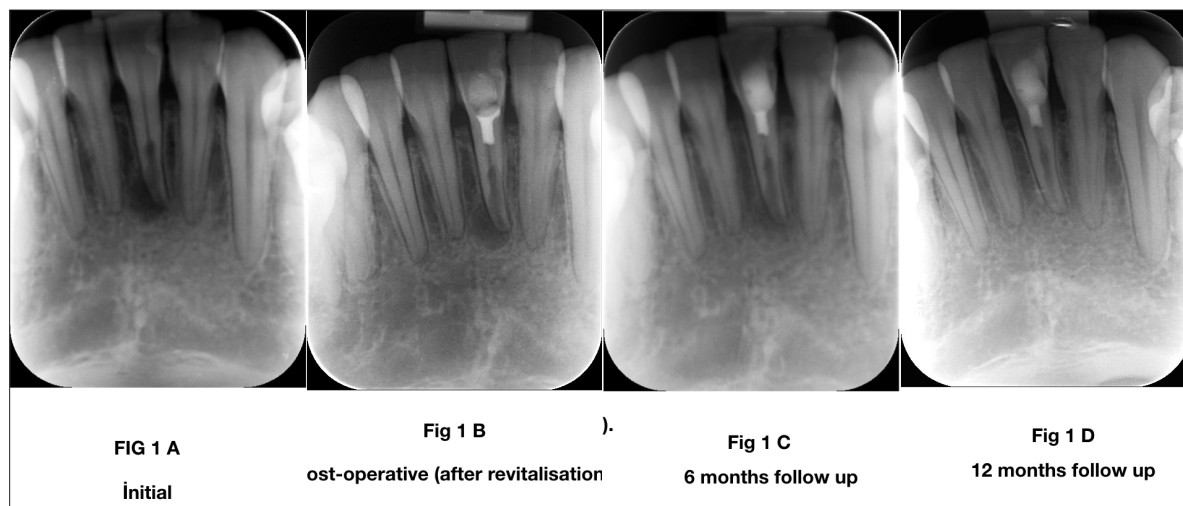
A-D. Radiographic images.
